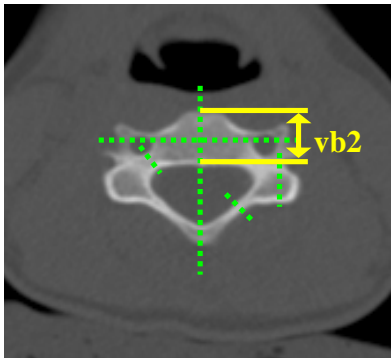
CT image slice of the cervical spine with dashed lines indicating the planes that re-slices were made on, and example of the vb2 measurement.
